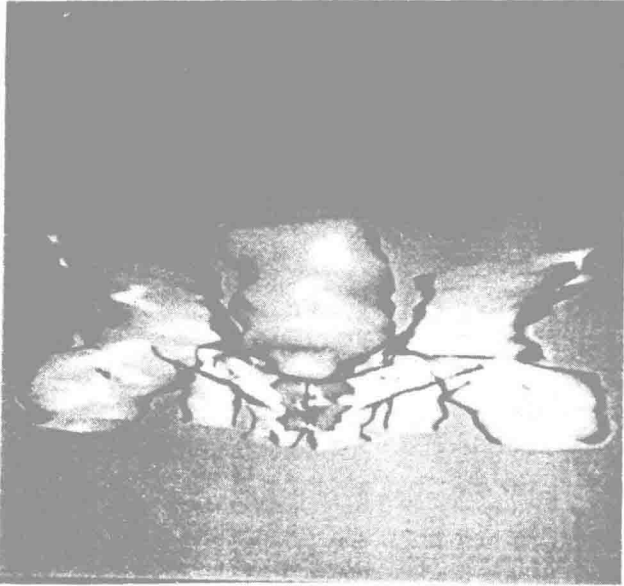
Smooth-shaded display with multiple light sources and transparent object of male pelvis from CT scans.
